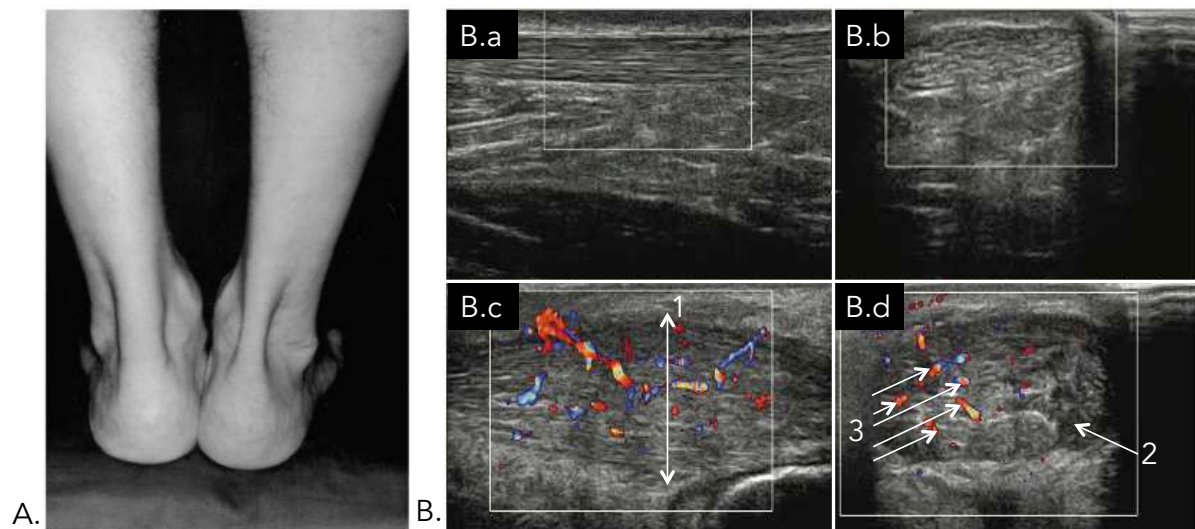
Achilles tendinopathy clinical aspect and ultrasound imaging. *Panel A: picture of patient’s ankles from a posterior view. The left Achilles tendon presents a pronounced swelling. From Maffulli et al. (2004). Panel B: ultrasound image of Achilles tendons with color Doppler. Longitudinal (B.a) and transverse (B.b) images of an asymptomatic tendon. Tendon shows normal echo texture with no Doppler signal. Longitudinal (B.c) and transverse (B.d) images of a symptomatic Achilles tendon show significant thickening of the tendon (arrow 1), the presence of hypoechoic areas (arrow 2), and significant Doppler signal (arrows 3). From Docking et al. (2015).*
